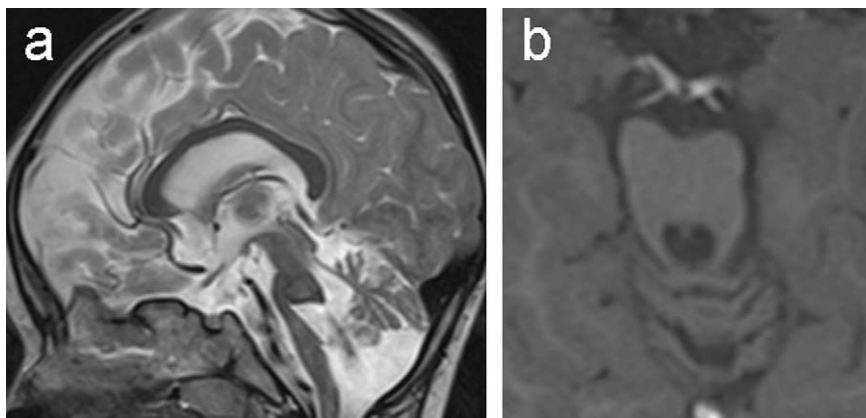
MRI of patient 2 at 2 years and 6 months. a Midsagittal T₂-weighted MRI showing the flat profile of the ventral side of the pons, the vaulted structure protruding into the fourth ventricle, shortening of the mesencephalic isthmus, and dysplastic superior vermis. b Axial T₁-weighted MRI revealing abnormal shape of the superior cerebellar peduncles producing a “molar tooth” appearance.
